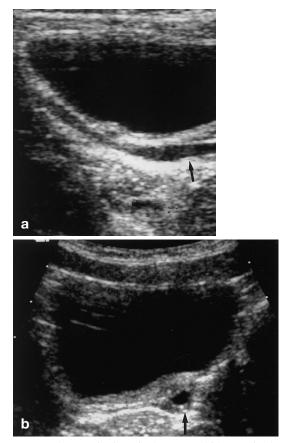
Poorly functioning single-system kidney mistaken for multicystic dysplastic kidney (MCDK). This girl had been followed for a presumed left MCDK, discovered on a prenatal ultrasound examination. EU and VCUG were done at three months of age. A single right kidney was identified; there was nonvisualization of the left kidney. An ectopic ureteral orifice was not a concern at that time, as she was still in diapers. Ultrasonography was performed at ages 7 months, 2 years, and 3 years 4 months. US, done at age 2, demonstrated a 2.7 cm small dysplastic kidney presumed to be multicystic and nonfunctioning, on the left and compensatory hypertrophy on the right. A dilated left ureter was present but it was not recognized. A left kidney was not found on subsequent US examinations. She underwent delayed toilet training at the age of 4 years 6 months. Over the next 6 months, her mother noticed that her underwear was always damp and told her pediatrician. He thought it was probably not significant but recommended that they tell the radiologist during her next scheduled US. That study (a, longitudinal and b, transverse) at age 5 years 4 months demonstrated a dilated left ureter that ended below the bladder (arrows). The left kidney was not seen. A DMSA scan and contrast-enhanced CT (not shown) revealed the small, dysplastic left kidney, which was removed. Postoperatively, she was dry for the first time in her life
